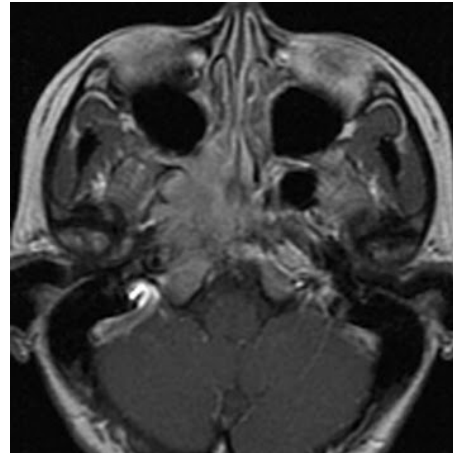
MRI T1W axial image after gadolinium contrast enhancement showing right nasopharyngeal carcinoma with extension into the sphenoid sinus, cavernous sinus, petrous apex and pterygopalatine fossa.
